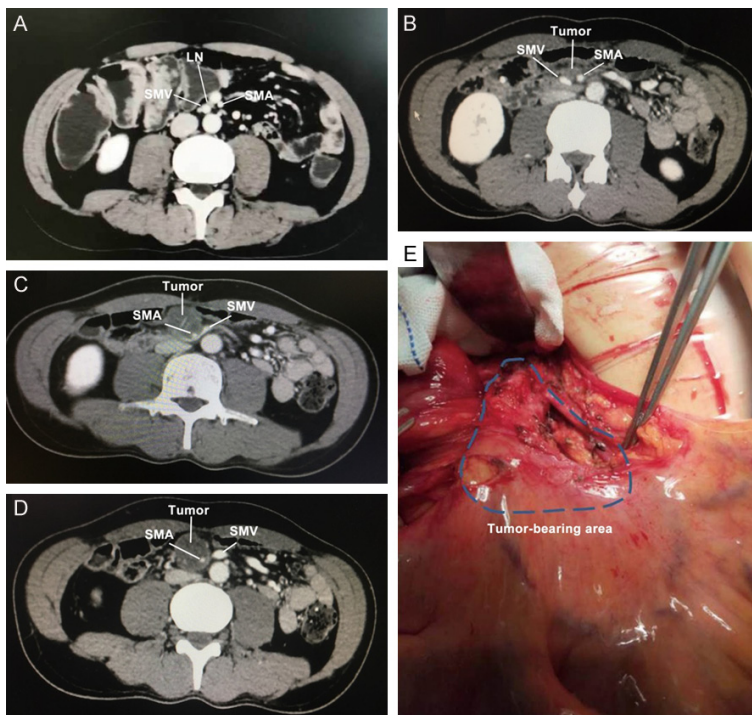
A case of lymph node metastasis in target area. A. An abnormally enlarged lymph node was observed between SMV and SMA on preoperative CT image. B-D. The assessment of tumor progression in a follow up CT 6 years after surgery. E. Intraoperative photo during reoperation. Dashed box denoted the tumor region. LN; lymph node.
